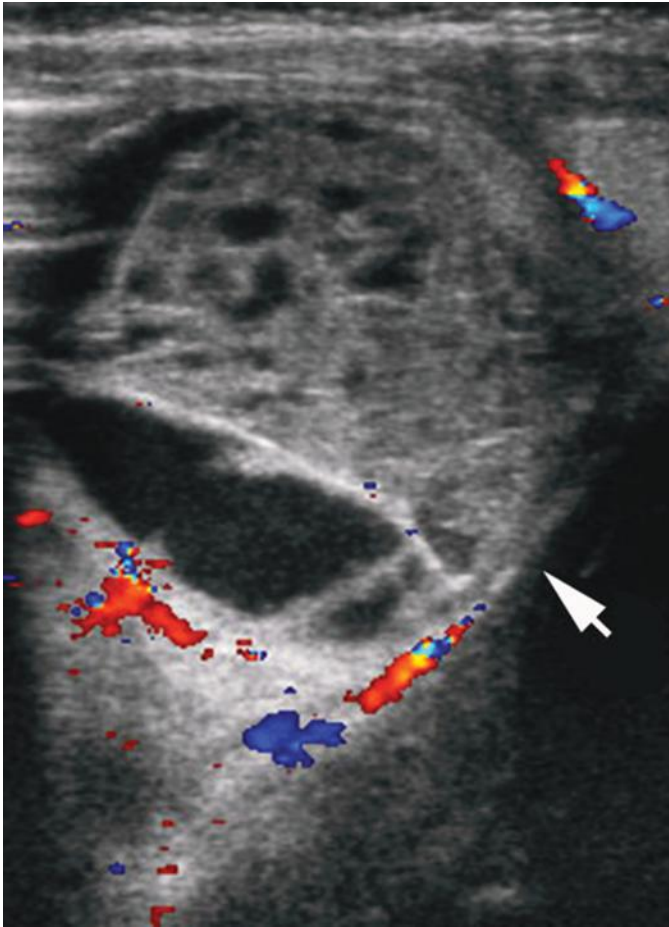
Prenatally detected ovarian cyst complicated by torsion. Sagittal postnatal ultrasound image obtained at 37 days of age shows a left adnexal cyst containing heterogeneous, nonvascular, moderately echogenic material consistent with retracting blood clot (arrow). Follow-up ultrasound examination at 6 months of age documented resolution of the cyst. The left ovary could not be identified, in keeping with torsion resulting in infarction and loss of left ovarian parenchyma. The right ovary appeared normal (not shown).
